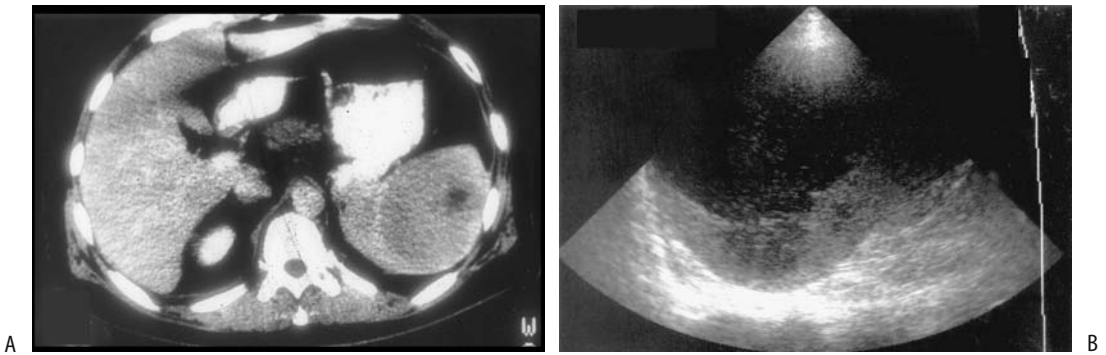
Solitary lymphoma. A: Transverse contrast-enhanced CT identifies a hypodense tumor with rim enhancement (arrow). B: The tumor is hypoechoic on longitudinal US (arrows). (Source: Dachman AH, Buck JL, Krishnan J, Aguilera NS, Buetow PC. Primary non-Hodgkin's splenic lymphoma. *Clin Radiol* 1998;53:137–142, with permission from the Royal College of Radiologists.)
